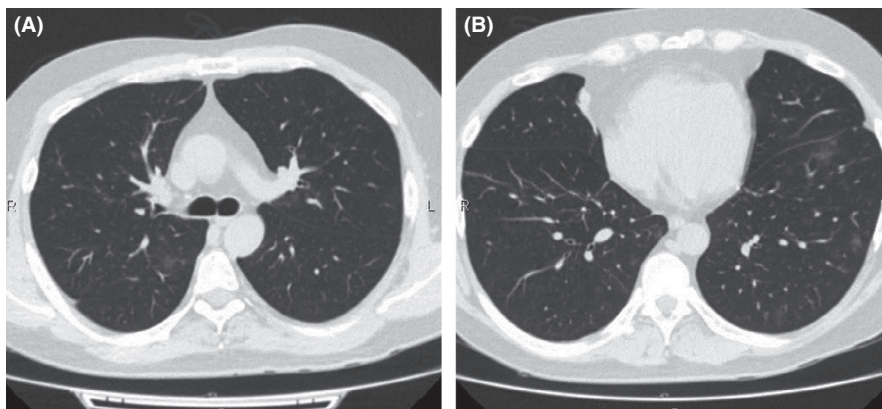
Minimal changes in the chest CT: the CT scan shows arrowed bilateral small ground-glass opacity (GGO) lesions
